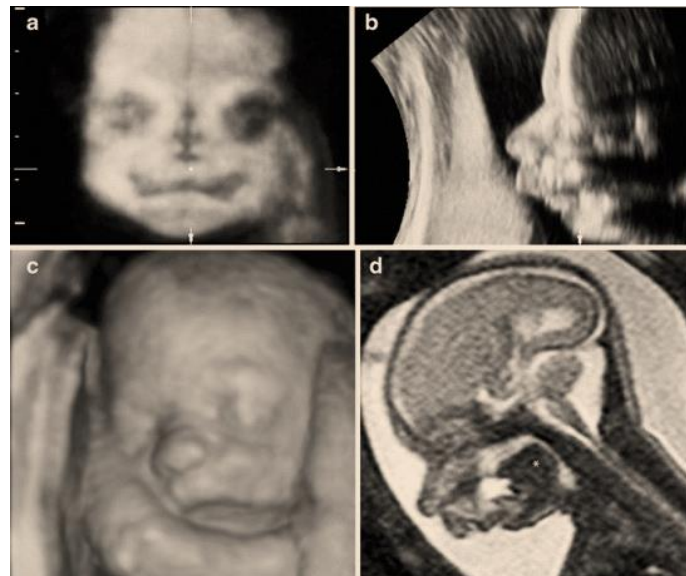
3D Ultrasound and MRI in PRS.
